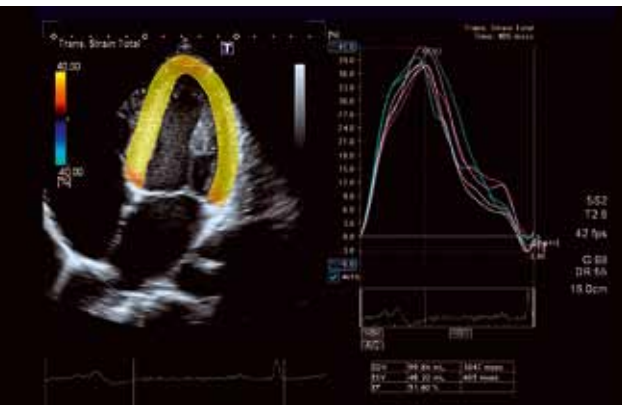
Apical four-chamber view of a healthy volunteer. Colour-coding from yellow to blue indicates strain from +40% to -40%.
